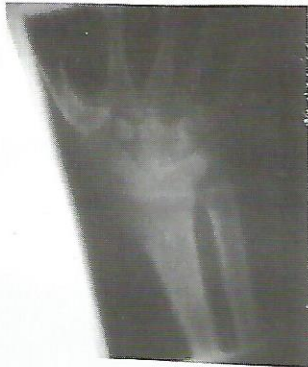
Postoperative x-ray showing excision of trapezium.
